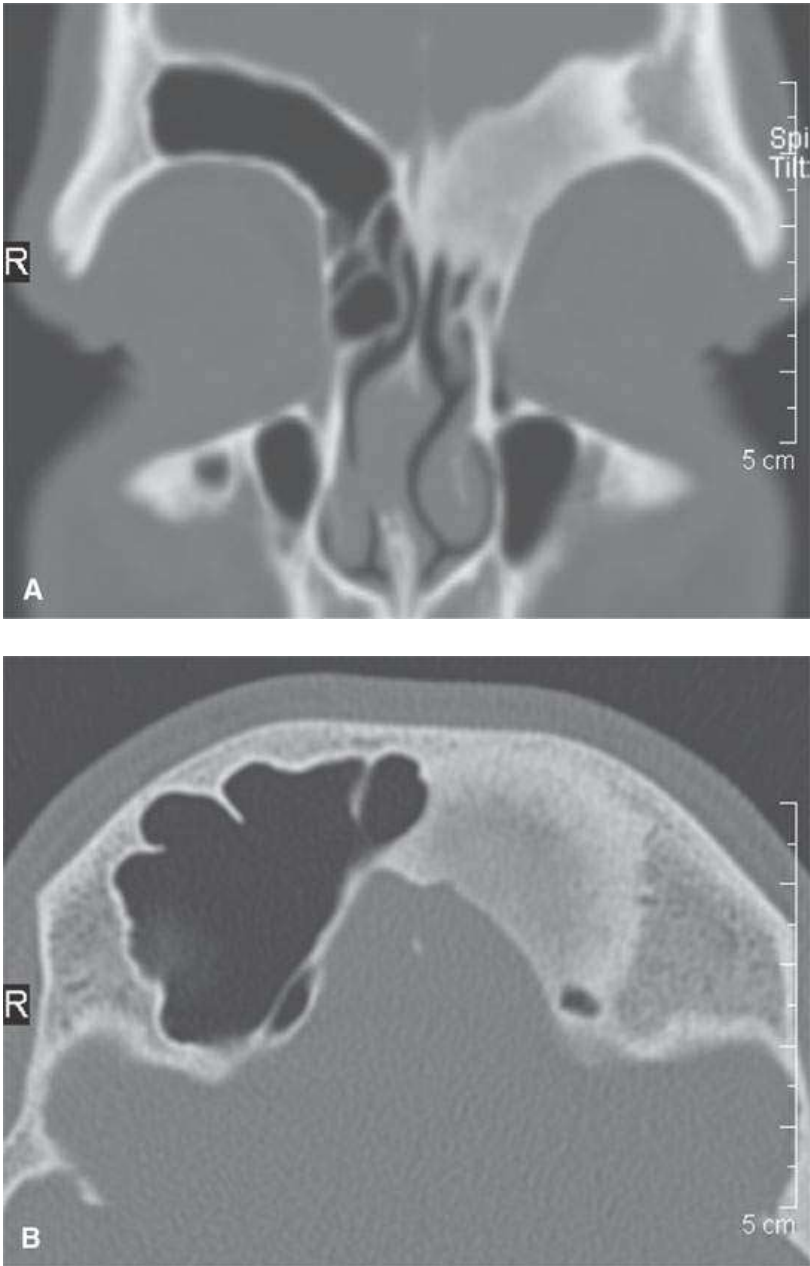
Mineralized matrices may or may not be specific. A, B: essentially diagnostic computed tomography of typical fibrous dysplasia.
